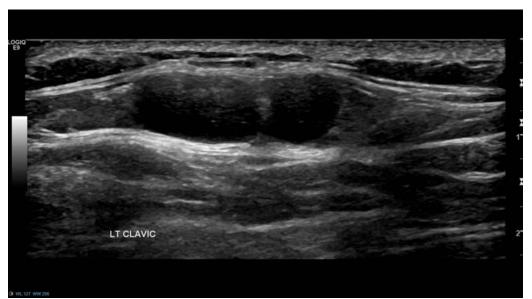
A 38-year-old woman, with no personal or family history of breast cancer, presented with a 4-week history of a palpable lump inferior to the left clavicle, which was first noticed approximately one week after receiving the first dose of the Pfizer-BioNTech COVID-19 vaccine in the left arm. Ultrasound of the left axilla and supraclavicular fossa (SCF) revealed normal-appearing axillary lymph nodes and a couple of lymph nodes up to 8mm in size in the area of interest, with appearances favoring benign reactive nodes. A bilateral mammogram showed no abnormalities. As the patient was due to have her 2nd vaccine dose in 5 weeks' time, she was advised to return for a 10-week follow-up ultrasound scan and clinical examination to ensure resolution. The patient reported that in the following weeks, the adenopathy progressively improved. Two days after receiving the 2nd vaccine dose, she again developed palpable SCF adenopathy that had disappeared completely by the time of her follow-up appointment. Permission to publish the images was obtained from Garreffa et al.³⁰, European Journal of Cancer, published online: October 11, 2021.
